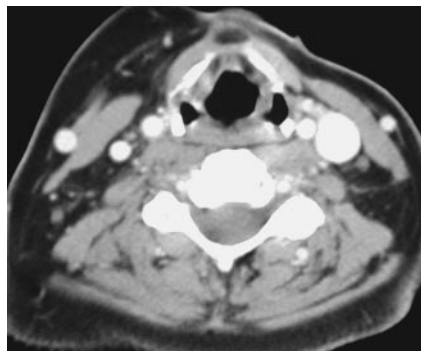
Patient has undergone resection of oropharyngeal squamous cell carcinoma, and left SND (levels I, II, and III). Postoperative CT scan of 3-mm-section thickness was obtained several months following surgery. There is marked paucity of fat beneath the left SCM muscle, and the muscle lies directly on top of the internal jugular vein.
